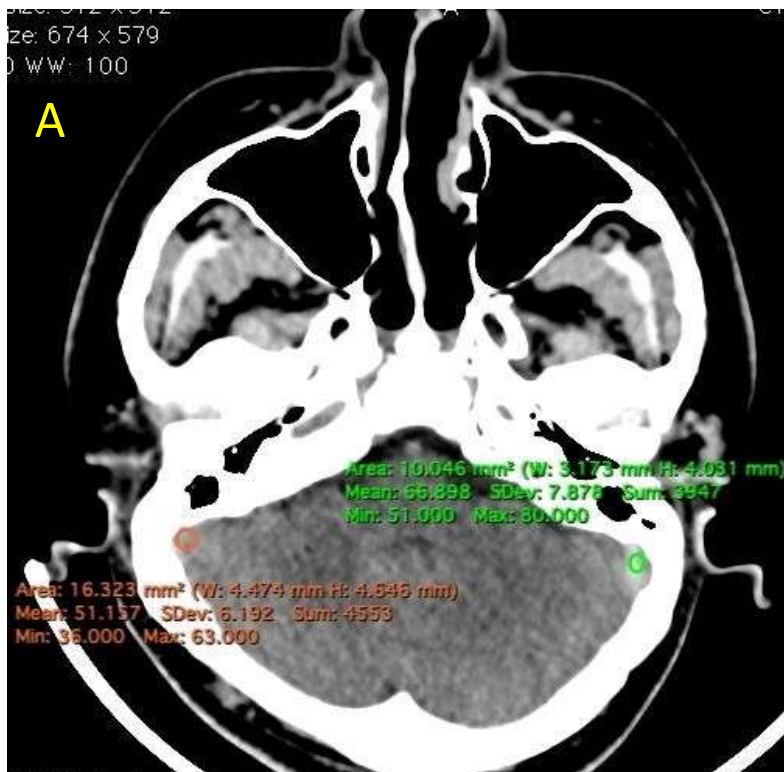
axial sections of CT brain (A) showing HU of 67 in left transverse sinus with a corresponding filling defect in (B) on CT venography of thrombosis.
